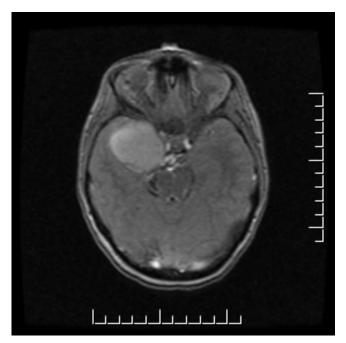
MRI brain demonstrates large extra-axial cystic and peripherally enhancing mass in the right middle cranial fossa, unchanged in morphology and size with stable degree of mass effect on the surrounding structures and bony remodeling of the right maxillary sinus and sphenoid sinus. There was no hydrocephalus, midline shift, restricted diffusion or any other intracranial lesions. Peripherally enhancing cystic structure along the trajectory of the right trigeminal nerve most likely representing a cystic schwannoma with stable mass effect on the surrounding structures and chronic osseous remodeling of the maxillary and sphenoid sinuses. There was no involvement of the hypothalamus, or the third or fourth ventricle.
